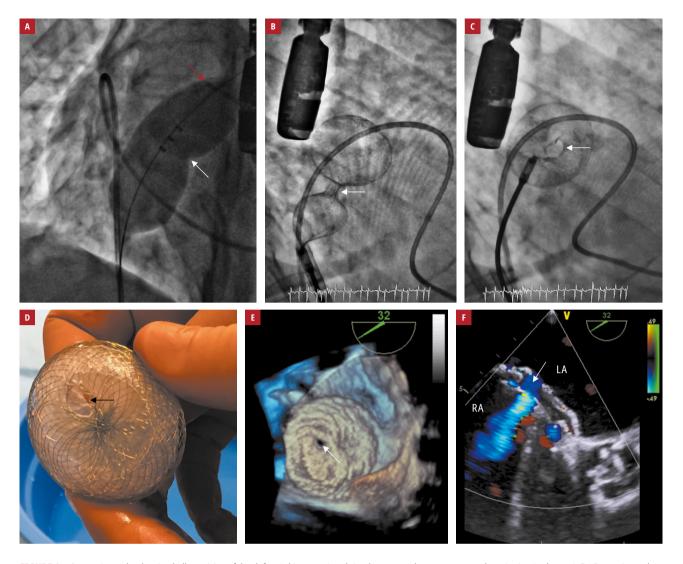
A – angiography showing balloon sizing of the defect (white arrow) and simultaneous pulmonary artery catheterization (red arrow); B, C – angiography performed during the implantation procedure showing the fenestrated ASD occluder (FASD; arrows) just before the final locking (B) and after release (C); D – the FASD, a self-expanding nitinol wire mesh device with fenestration (fenestration diameter, 6 mm; arrow); E, F – final transesophageal echocardiography visualizing a 3-dimensional left atrial en face view of the FASD (E) and the shunt through the FASD (F); fenestration indicated by the arrows
